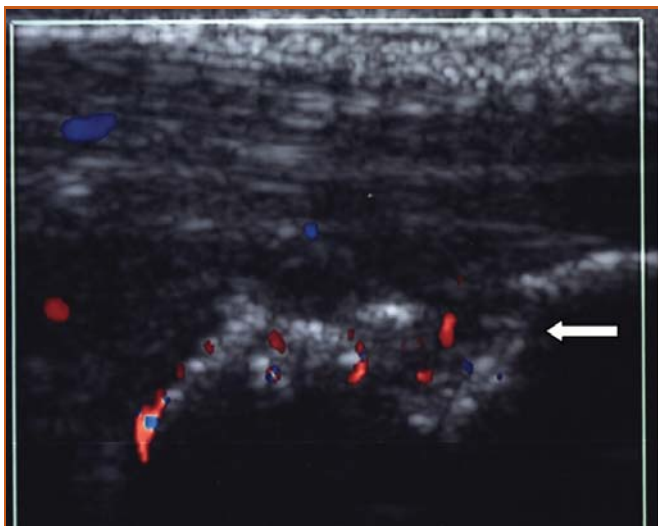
Ultrasound colour Doppler shows cortical irregularity with increase in thickness and colour flow at Achilles tendon insertion in calcaneum. The findings are suggestive of active enthesitis (arrow). (Courtesy of Dr. L. F. Chau)
